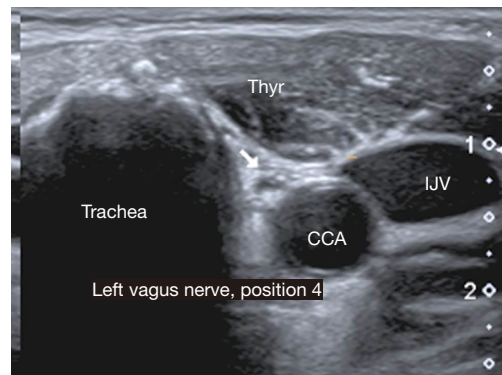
Ultrasound aspect of the left vagus nerve (white arrow) in position 4. THYR, thyroid lobe; IJV, internal jugular vein; CCA, common carotid artery.
